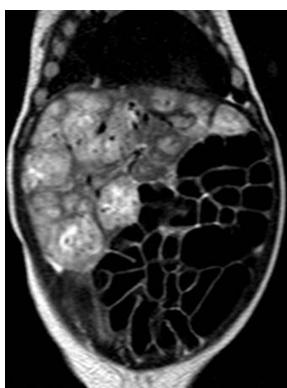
Abdominal magnetic resonance imaging-contrast. Diffuse hepatic hemangioma that nearly totally replaces the liver.
